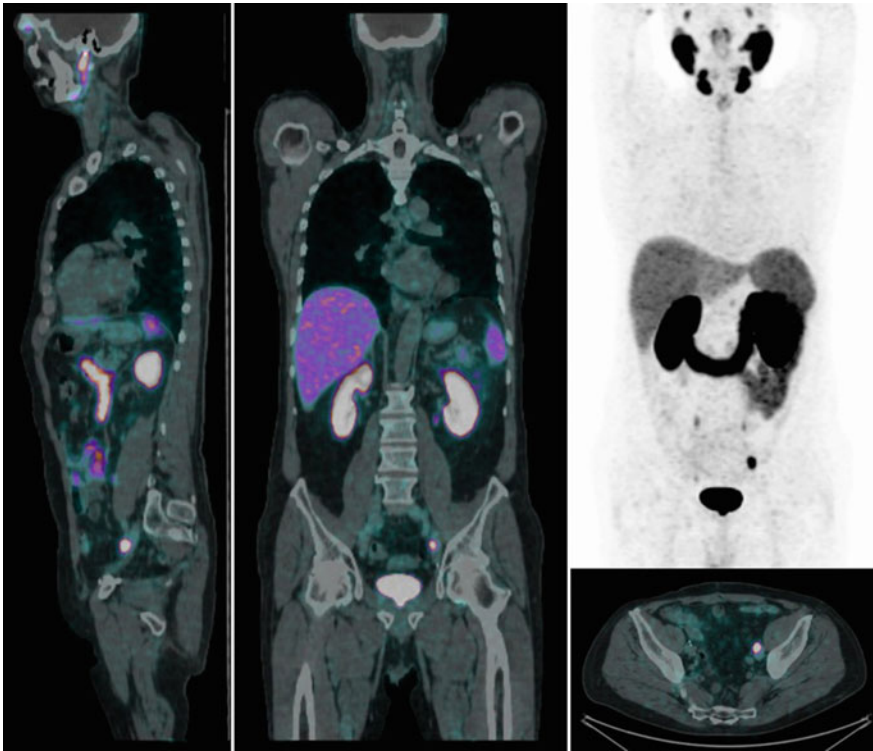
MIP and multi-axial views of ^{68}Ga -PSMA PET/CT in a PCa patient with biochemical relapse (PSA 1.86 ng/ml) after radical prostatectomy; the nodal involvement in the left iliac region is clearly visible in all views, respectively, from left to right: sagittal, coronal, MIP plus axial
